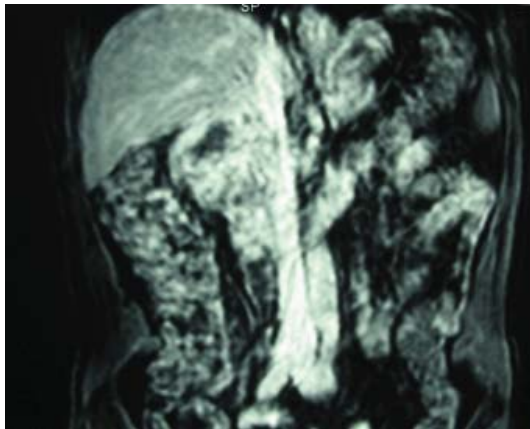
MRI showing tumour compressing inferior vena cava.
